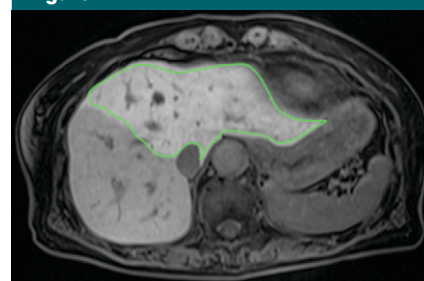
Patient 22. Axial 3D GRE T1-weighted MR image with fat suppression (3.5/1.42; flip angle, 15°) at 20 minutes after gadoxetate disodium administration obtained in a 78-year-old woman with hilar bile duct carcinoma. Portal vein embolization was performed in right branch of portal vein, and the signal intensity in the right hepatic lobe was decreased compared with that in the left hepatic lobe. The rHUI/HUI was 0.43, whereas the rV_L/V_L was 0.32 and lower than the rHUI/HUI. Green lines = outlines used to obtain rHUI and rV_L .
